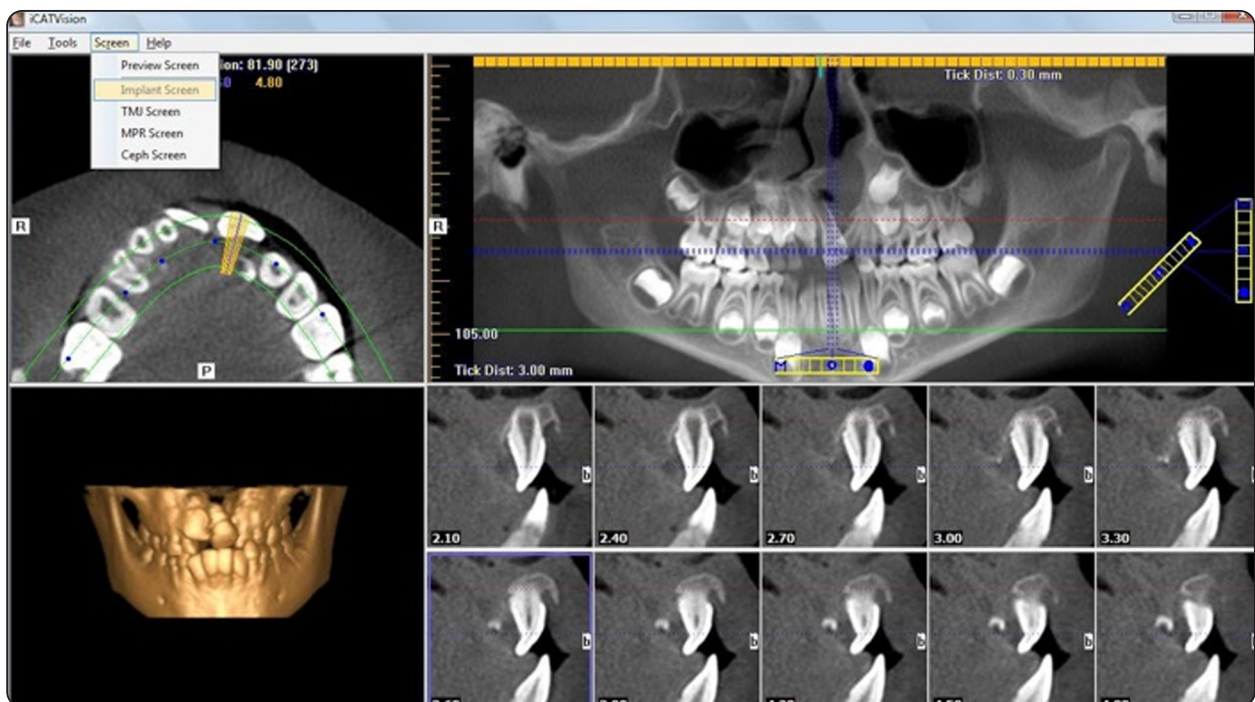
Implant screen derived from the CBCT scans.
